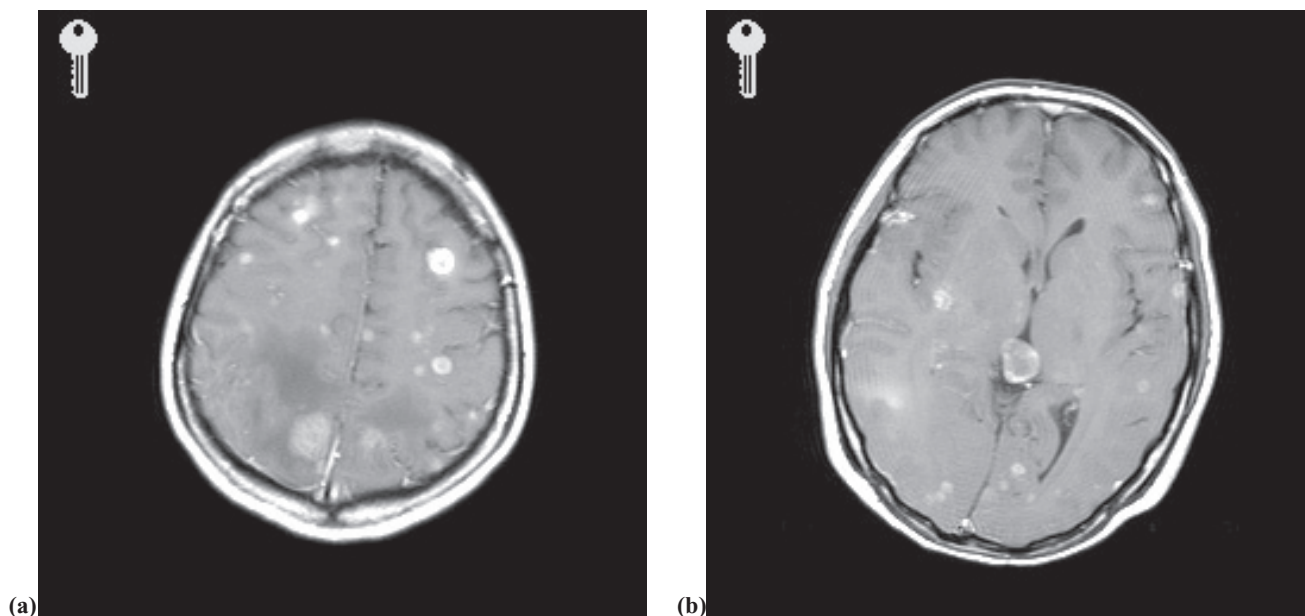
Day 4 axial post-gadolinium T1-weighted MRI prior to whole brain radiation, demonstrating multiple small enhancing lesions throughout brain parenchyma (a) and (b).
